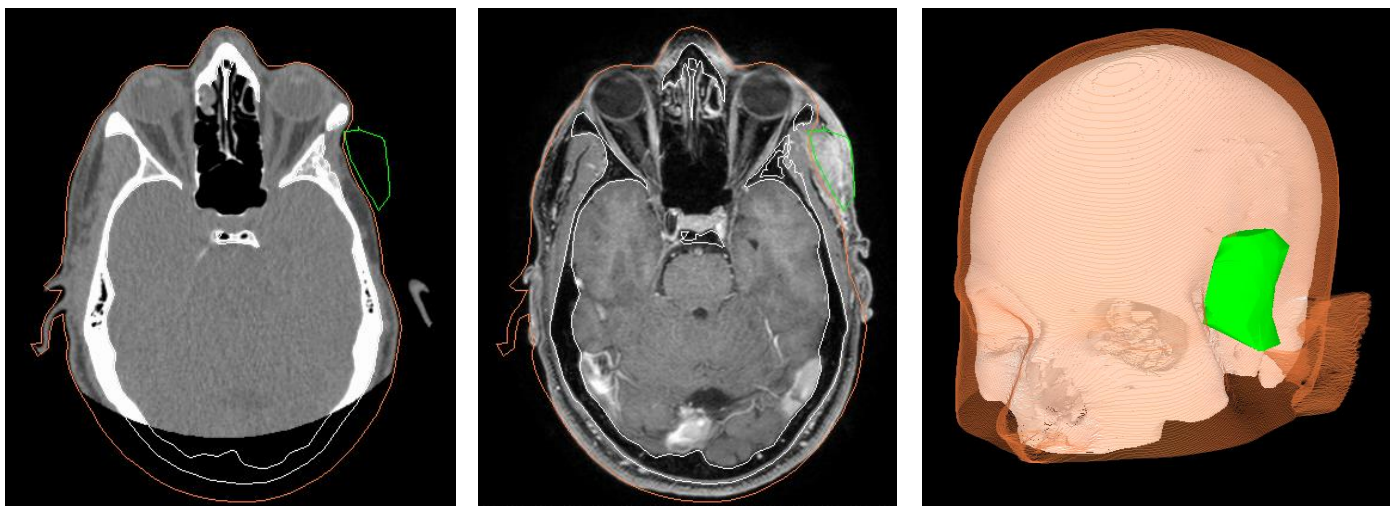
left: Post-operative CT scan. Middle: preoperative MRI-scan. Right: 3D rendering of the skull, skin and tumor. On the CT-scan the area of the tumor is visible in green and clearly demonstrates an adequate resection of the tumor area (green area is gone on the post-operative CT-scan).
